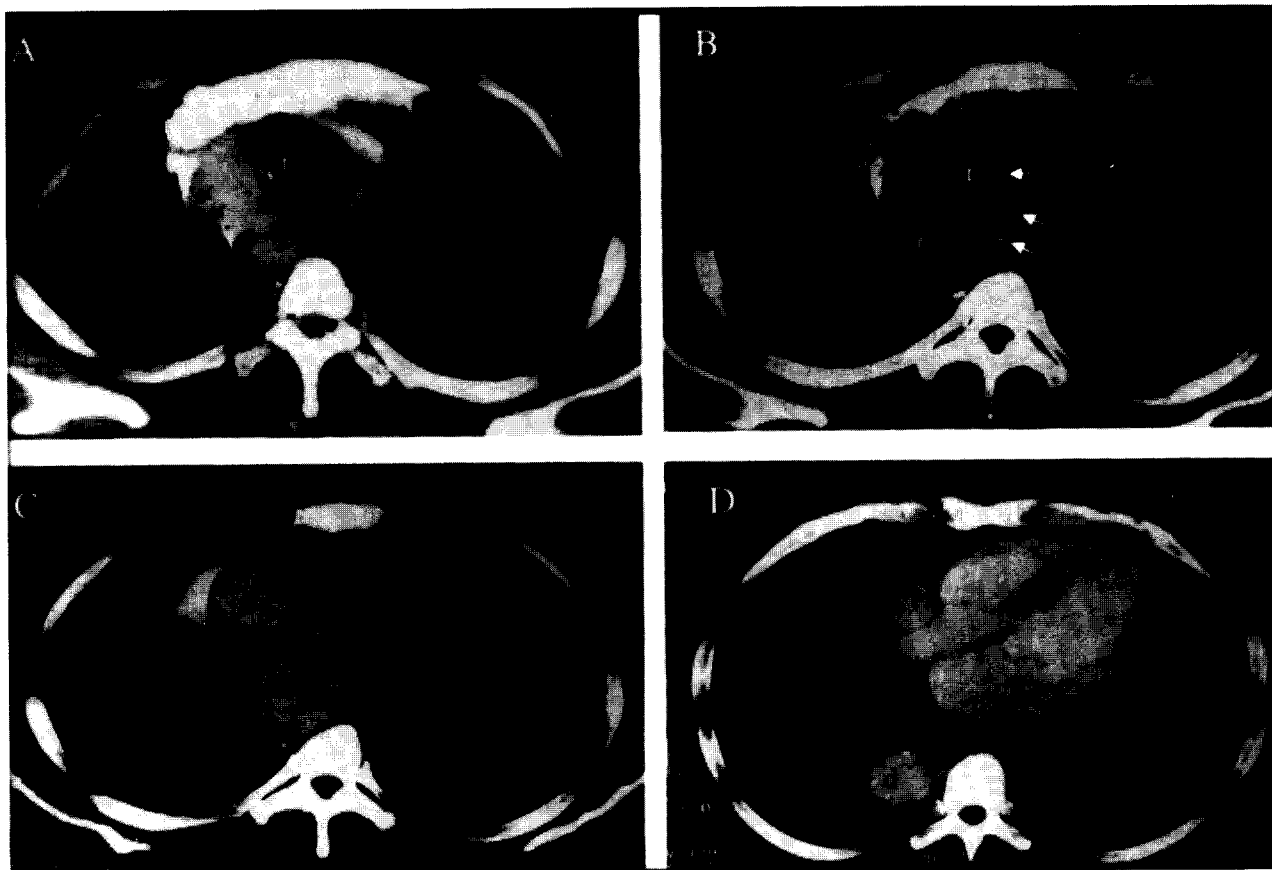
CT on admission shows: (A) Right aortic arch with intimal calcification (long black arrow) and a dissection flap (short black arrows) at its lateral aspect. t = trachea. (B) Kommerell's diverticulum (K) with aberrant left subclavian artery running behind the trachea (t) and esophagus (long white arrow). The dissection flap also extends into the aberrant left subclavian artery (short white arrows). Short black arrows: dissection flap. (C) Aortic dissection spares the ascending aorta (a) but involves the proximal portion of descending aorta, which is separated into false (F) and true lumens (T). (D) The middle portion of the right descending aorta (d) is free of dissection.
